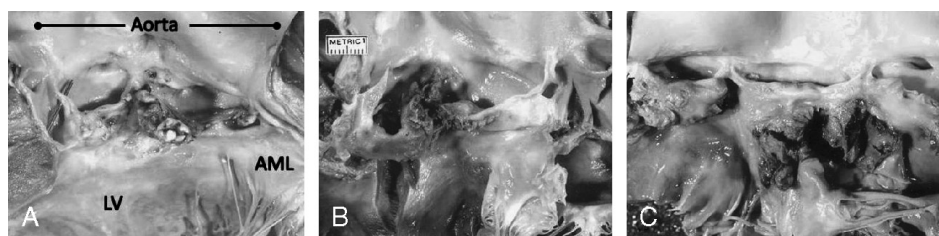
Active IE: opened aortic valves exposing vegetations that have destroyed the 2 aortic valve cusps to varying degrees. A, Valve in a 35-year-old man who had alpha streptococcus IE with a ring abscess and severe AR. This patient was an opiate addict who probably had infection in the past that healed because the heart at necropsy weighed 760 g. The cusps are located anterior and posterior, and a raphe is present in the anterior cusp. The infection caused severe AR. AML = anterior mitral leaflet; LV = left ventricle. B, Valve in a 60-year-old man. The cusps are located anterior and posterior, and vegetative material is particularly heavy in the area of the raphe. This patient had the triad of active IE, meningitis, and pneumonitis. The vegetative material had burrowed into the aortic wall causing a large ring abscess and complete heart block. The patient was a habitual alcoholic. The last episode of IE produced acute symptoms beginning 7 days before death. Blood cultures grew *Streptococcus pneumoniae*. Complete heart block developed 2 days before death. Six months before death he had undergone cardiac catheterization because of severe AR: an 11 mm Hg peak transvalvular pressure gradient and severe AR were found. C, Bicuspid valve in a 45-year-old man with pre-existing aortic valve stenosis who was hospitalized 12 days before death because of confusion, fever, and leukocytosis. Echocardiogram showed vegetation on the aortic valve, and blood cultures grew *Streptococcus milleri*. Computed tomogram (CT) disclosed multiple cerebral infarcts. The patient weighed >135 kg. At autopsy, the heart weighed 920 g. The 2 aortic valve cusps were calcified. The vegetative material had burrowed into the right ventricular cavity. Emboli were present in the brain. Additionally, there was diffuse fibrinous pericarditis. Both left ventricular papillary muscles were necrotic in the absence of significant coronary disease. Both aortic valve cusps were perforated by the vegetation.
